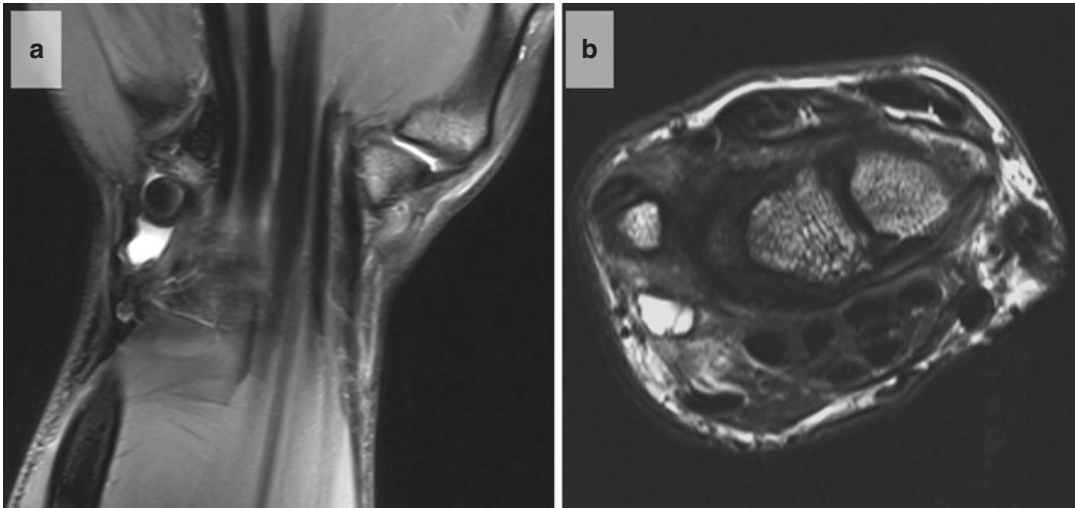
MRI of an effusion with synovialitis in the distal radioulnar joint (a, coronary MRI image; b, axial projection)
